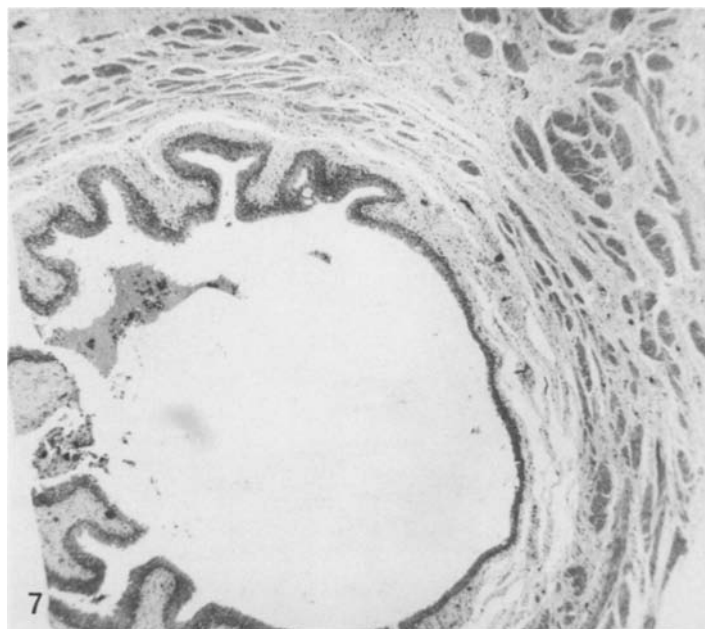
Minipig ureteric orifice four weeks after incision with ultrasonic scalpel. $\times 28$
